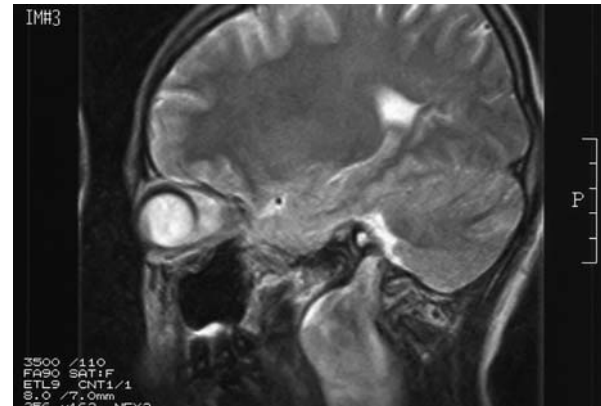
MRI findings. The top of the tumor grew into the jugular foramen.
